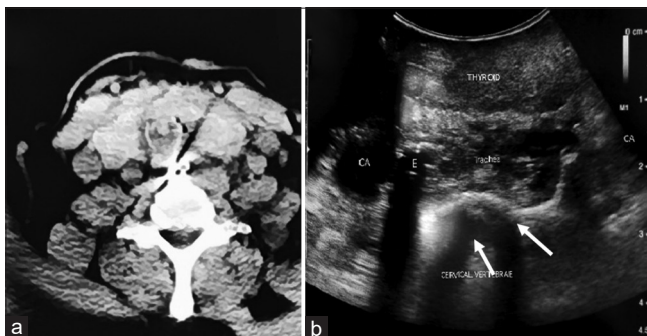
(a) Side-by-side comparison between computed tomography of the neck in axial view image and (b) corresponding sonographic image of the airway intraoperatively. White arrows show the posterior acoustic shadowing casted by the retained blade fragments. CA = carotid artery, E = oesophagus
